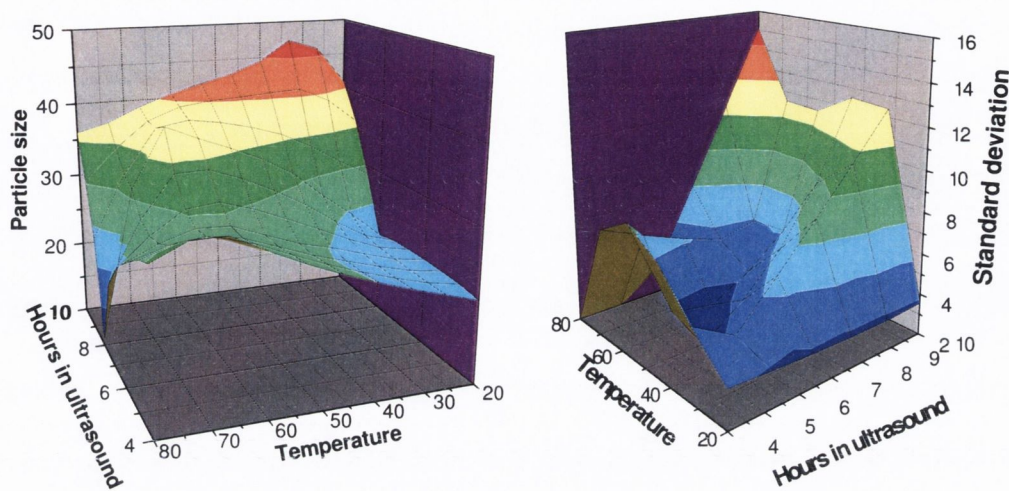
(a) Surface response curve for magnetite nanocrystals with varying temperature and time in ultrasound and the corresponding response measured as the particle size in nanometres; (b) Surface response curve for magnetite nanocrystals with varying temperature and time in ultrasound and the corresponding response measured as the standard deviation of particle size in nanometres.
